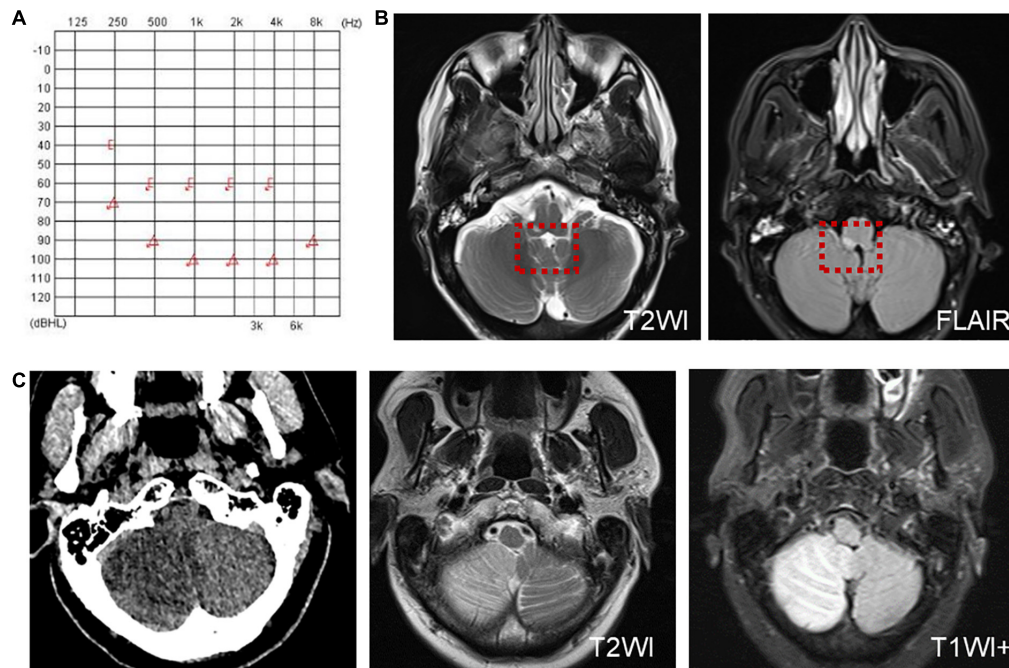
Examination results of patients with infarction of the cochlear and vestibular nuclei (A,B) and right cerebellar infarction (C). (A) PTA shows total deafness on the right side in a patient with infarction of the cochlear and vestibular nuclei. (B) MRI shows that the infarcted focus of the right medulla oblongata near the pons involved the cochlear nucleus and vestibular nucleus (red dotted line frame). (C) Cranial CT and MRI of the patient with right cerebellar infarction.
